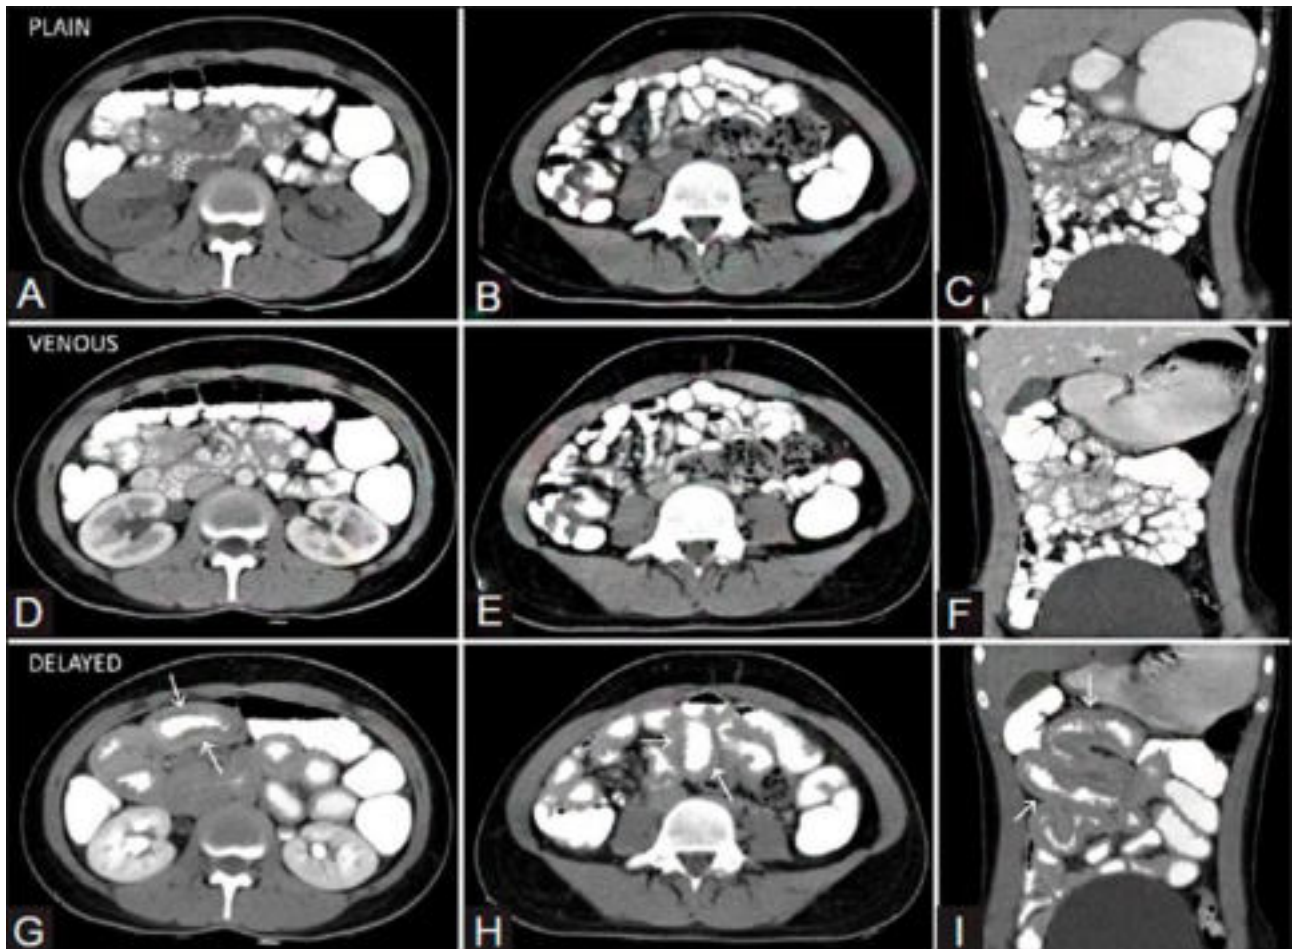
CT of the abdominal organs
